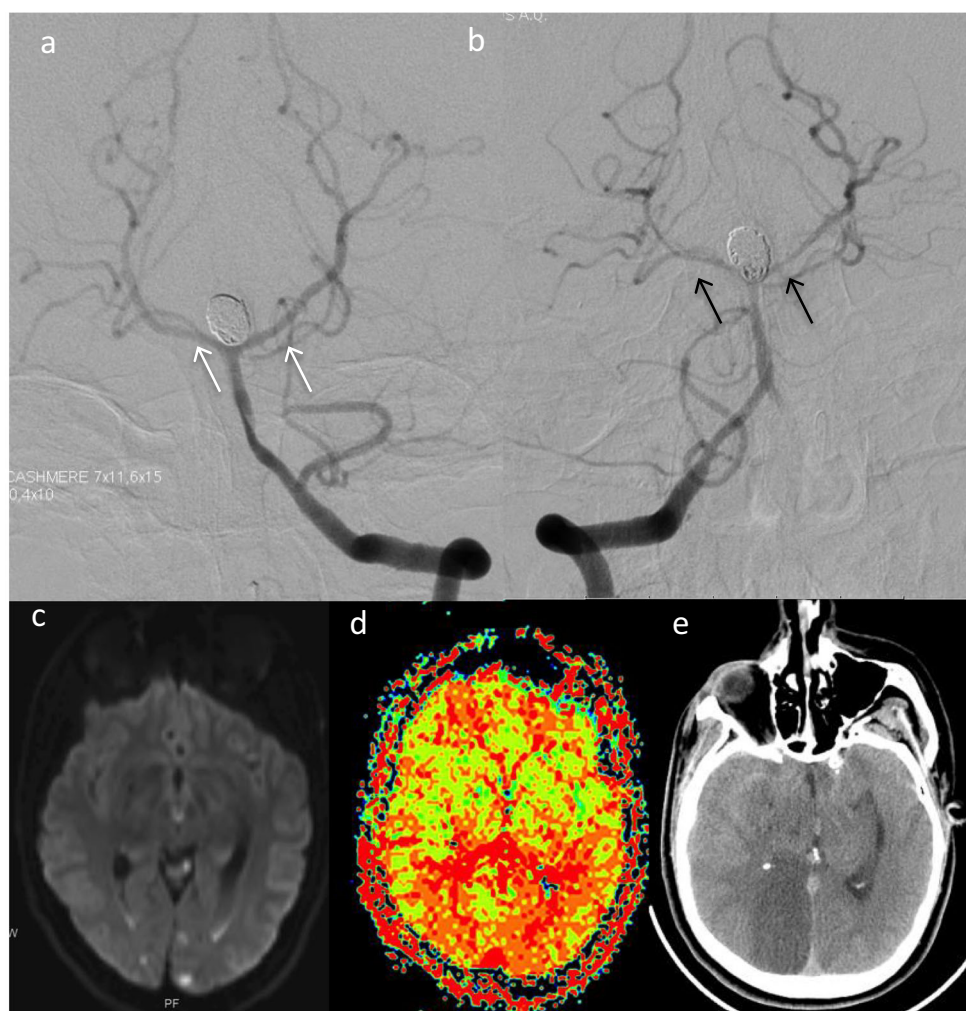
Forty-one-year-old patient with a ruptured basilar tip aneurysm. a DSA at admission, after coiling of the aneurysm. Normal diameter of basilar artery and posterior cerebral arteries (PCA) (white arrows). b DSA at day 7 post-SAH, showing reduction of the diameter of the basilar artery and both PCAs (black arrows). MRI performed at day 4 post-SAH showed small acute ischaemic lesions on both PCA territories, on DWI (c), and an increase of TTP on the same territory (d), reflecting hypoperfusion, with a DWI/PWI mismatch. e CT scan at day 10 after SAH, showing an acute ischaemic lesion on the right PCA territory, and global cerebral edema, that progressed despite aggressive treatment of vasospasm.
